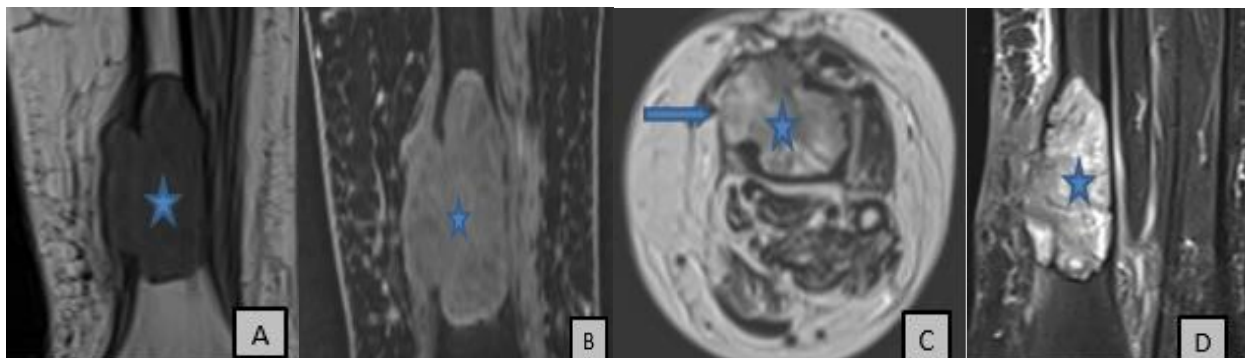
MRI of the left leg, A: sagittal T1, B: sagittal T1 FAT SAT post contrast product injecting, C: axial T2, and D: sagittal STIR
